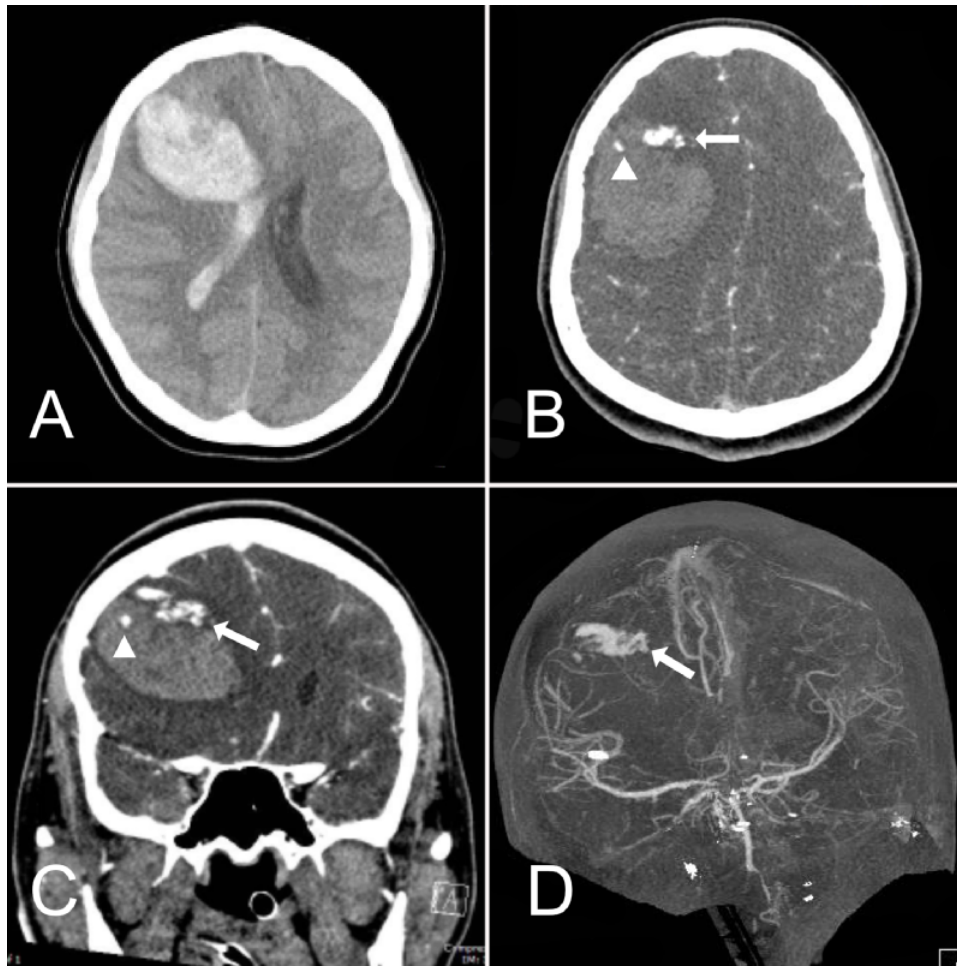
Preoperative imaging. A noncontrast head CT (A) demonstrates a large right frontal hematoma with extension into the right lateral ventricle. CTA axial (B), coronal (C), and 3D (D) reconstructions demonstrate the expanding hematoma, a radiographic “spot sign” (white arrowheads), and brain AVM nidus (white arrows). AVM, arteriovenous malformation; CTA, computed tomography angiography.
